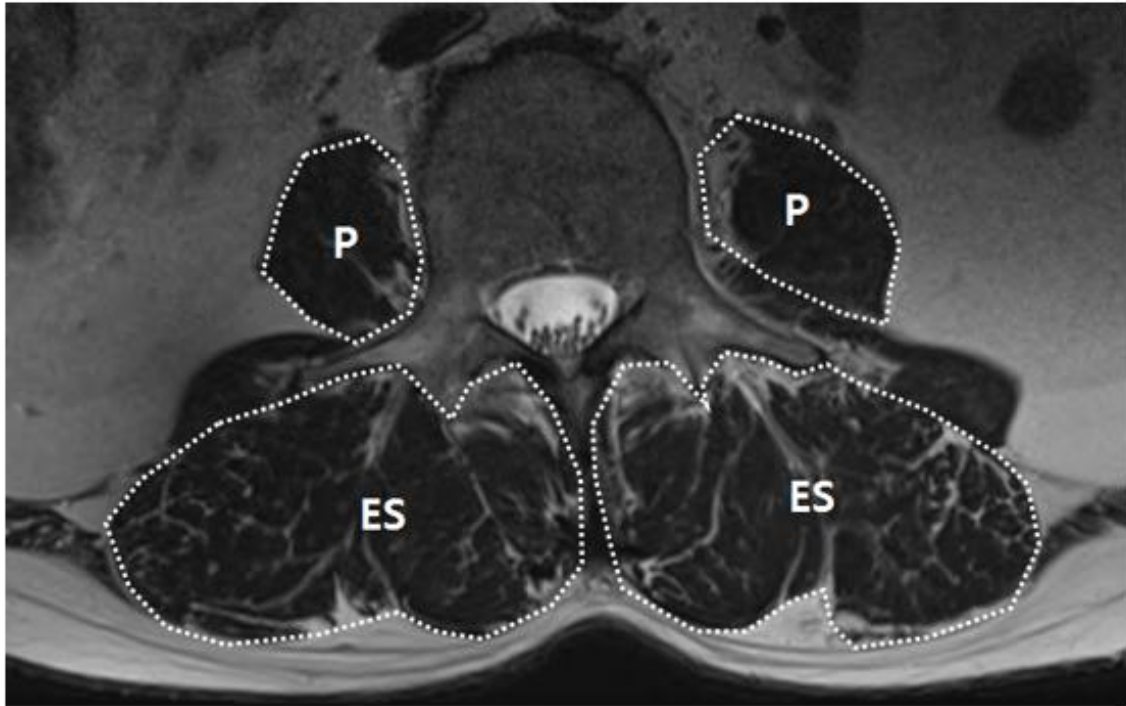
Erector spinae and psoas muscle CSA measurement by MRI
